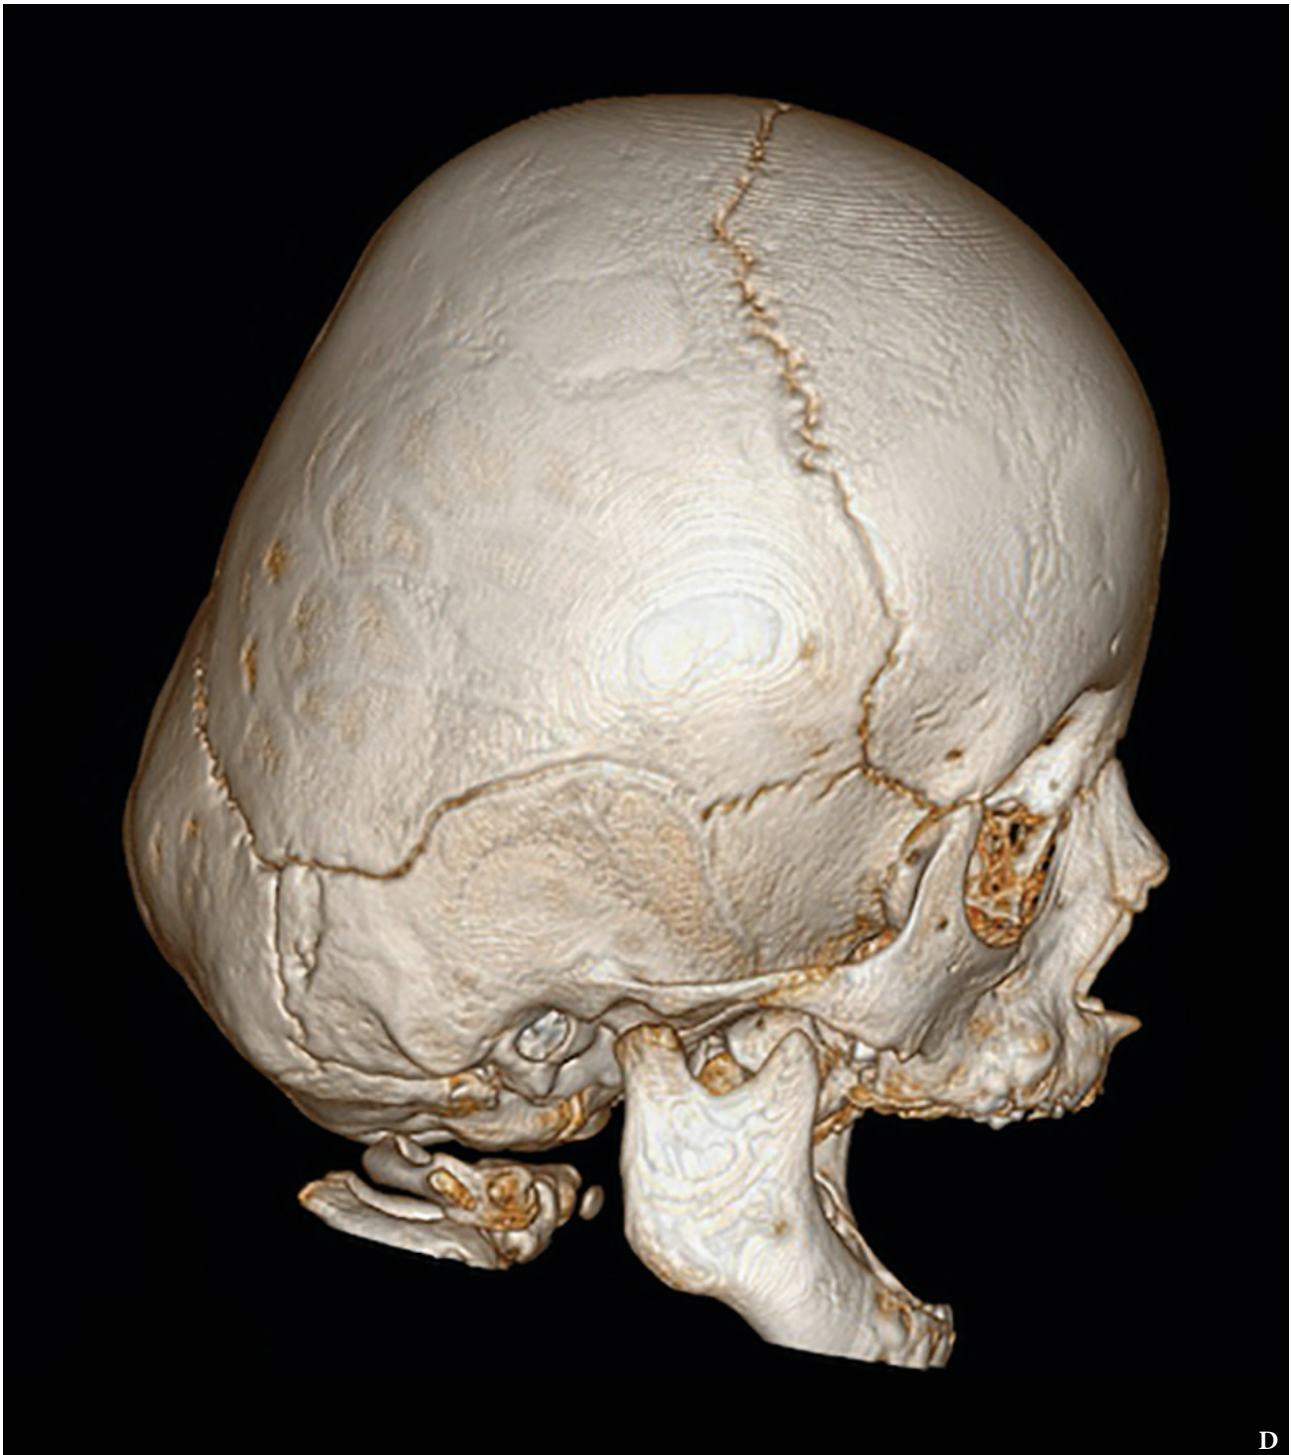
(cont'd). Right lateral view (D) of 3D-CT volume-rendered image of a 7-month-old boy with anterior plagiocephaly as a result of left coronal suture fusion which leads in flattening of the frontal bone on the affected side, and prominent frontal bossing to the contralateral side. There is also evident orbit asymmetry. The right coronal suture is still open.
